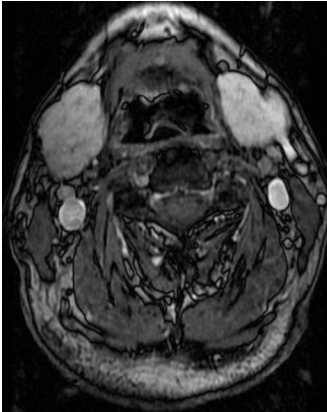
Magnetic resonance imaging of the salivary glands showing symmetrical bilateral enlargement of the submandibular gland (4.0 × 2.6 × 5.2 cm).
